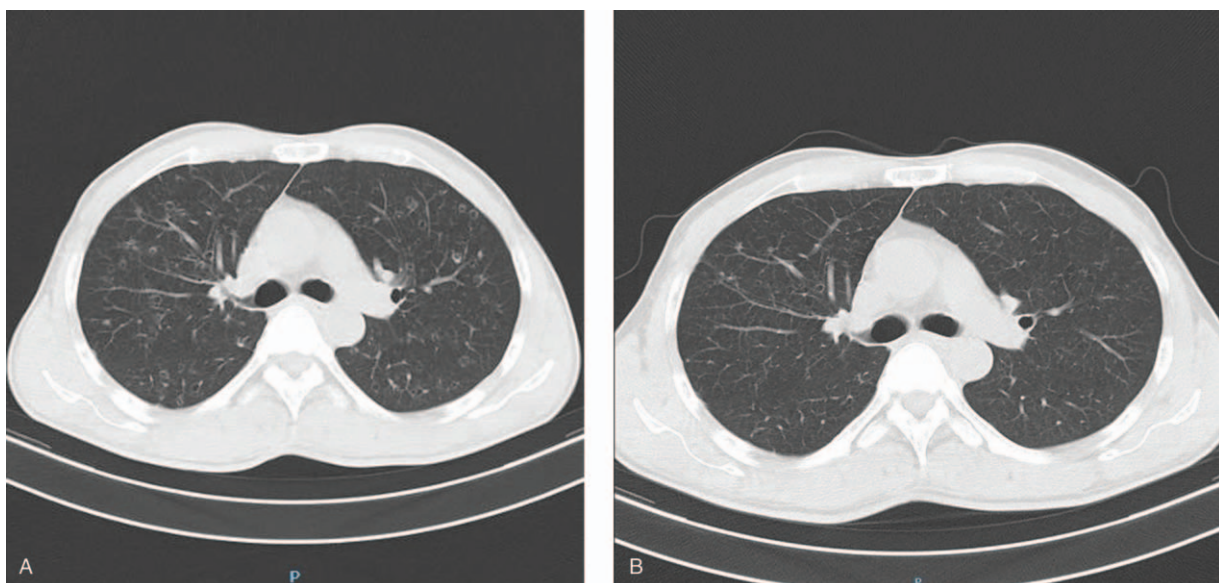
High-resolution computed tomography of the chest showed bilateral multiple micro-nodules and small-sized cyst lesions that were mainly located in the upper lobe (A); however, at the 2-month follow-up, most lesions had resolved (B).
